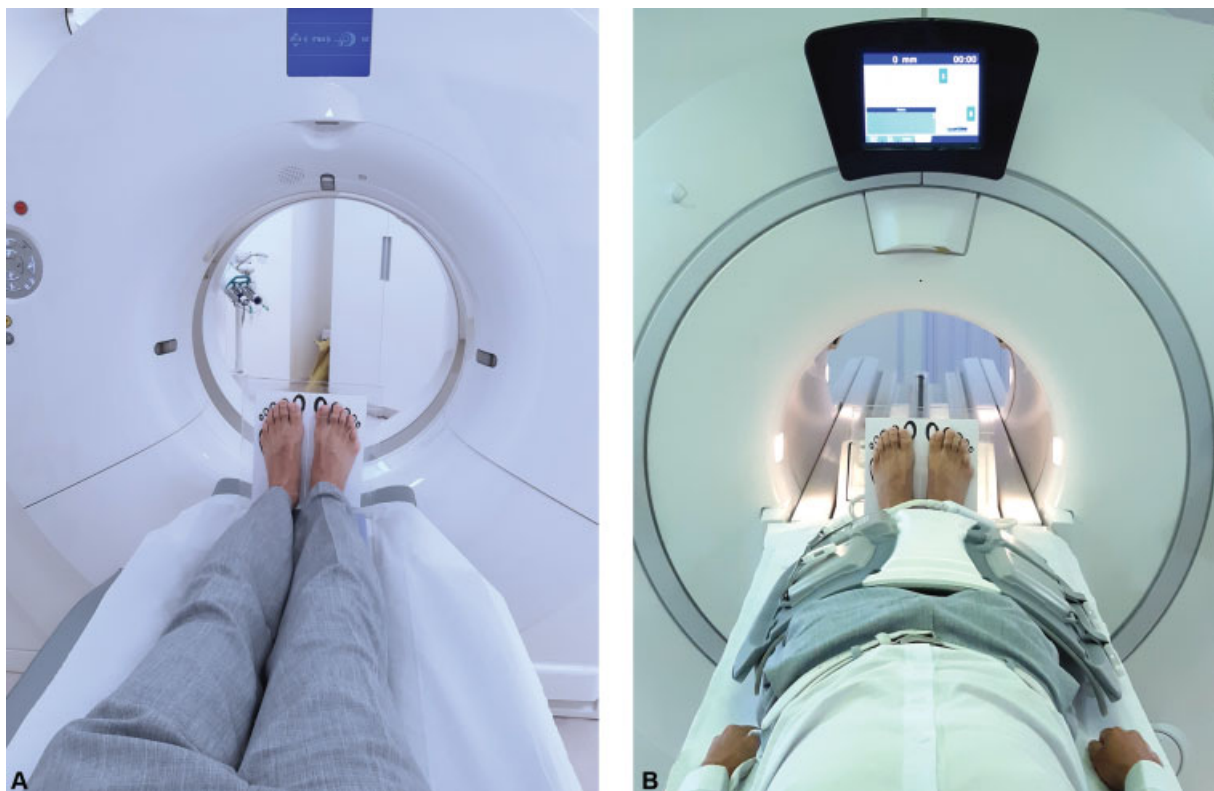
(A and B) Positioning in the CT and MRI with body coil, both with the acrylic supporting device.
